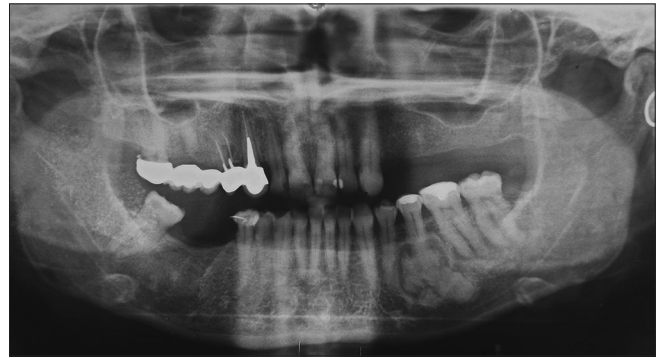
Orthopantomographic radiography that shows the presence of ground-glass appearance lesion apical to the 3.5 element
